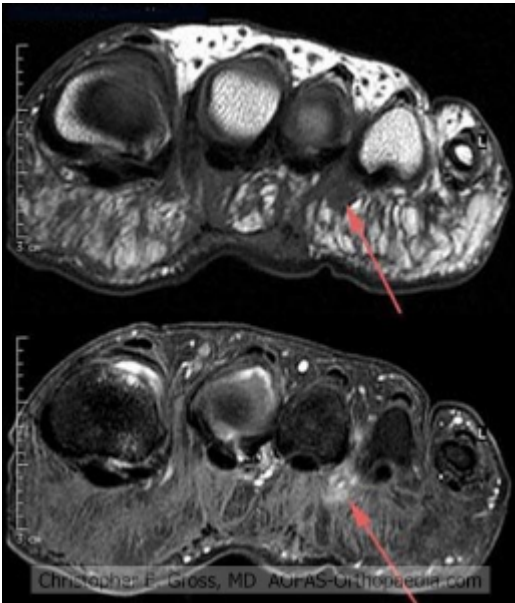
MRI of Morton's neuroma
